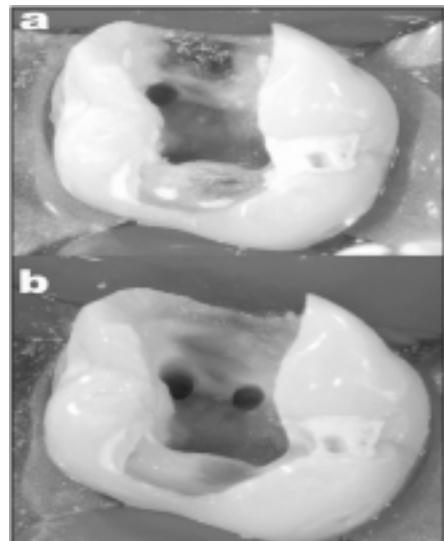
The orifice of the second mesiobuccal canal (MB2) in an upper firstmolar was located (a) and enlarged (b). Dentine spur at the orifice was effectively eliminated with the use of a diamond-coated ultrasonic tip, thus permitting easy location of the orifice of the canal.
